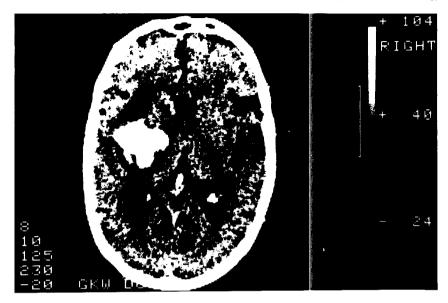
CT head scan demonstrating the left putamenal haemorrhage.
